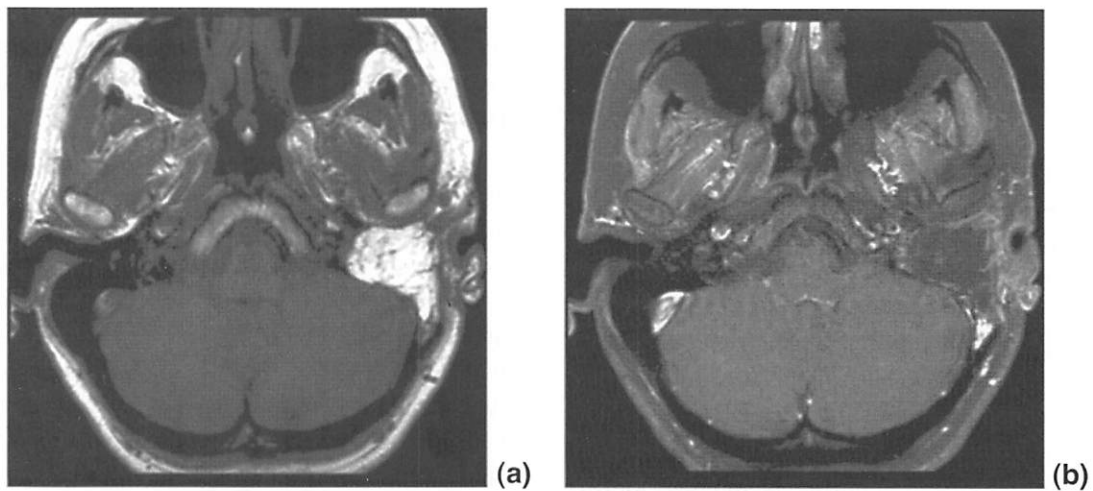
Postoperative axial MRI shows no sign of recurrence. The defect is obliterated using abdominal fat. Fat suppression technique is useful to reveal the adjacent pathology. (a; T1-weighted, b; T1-weighted with fat suppression).
